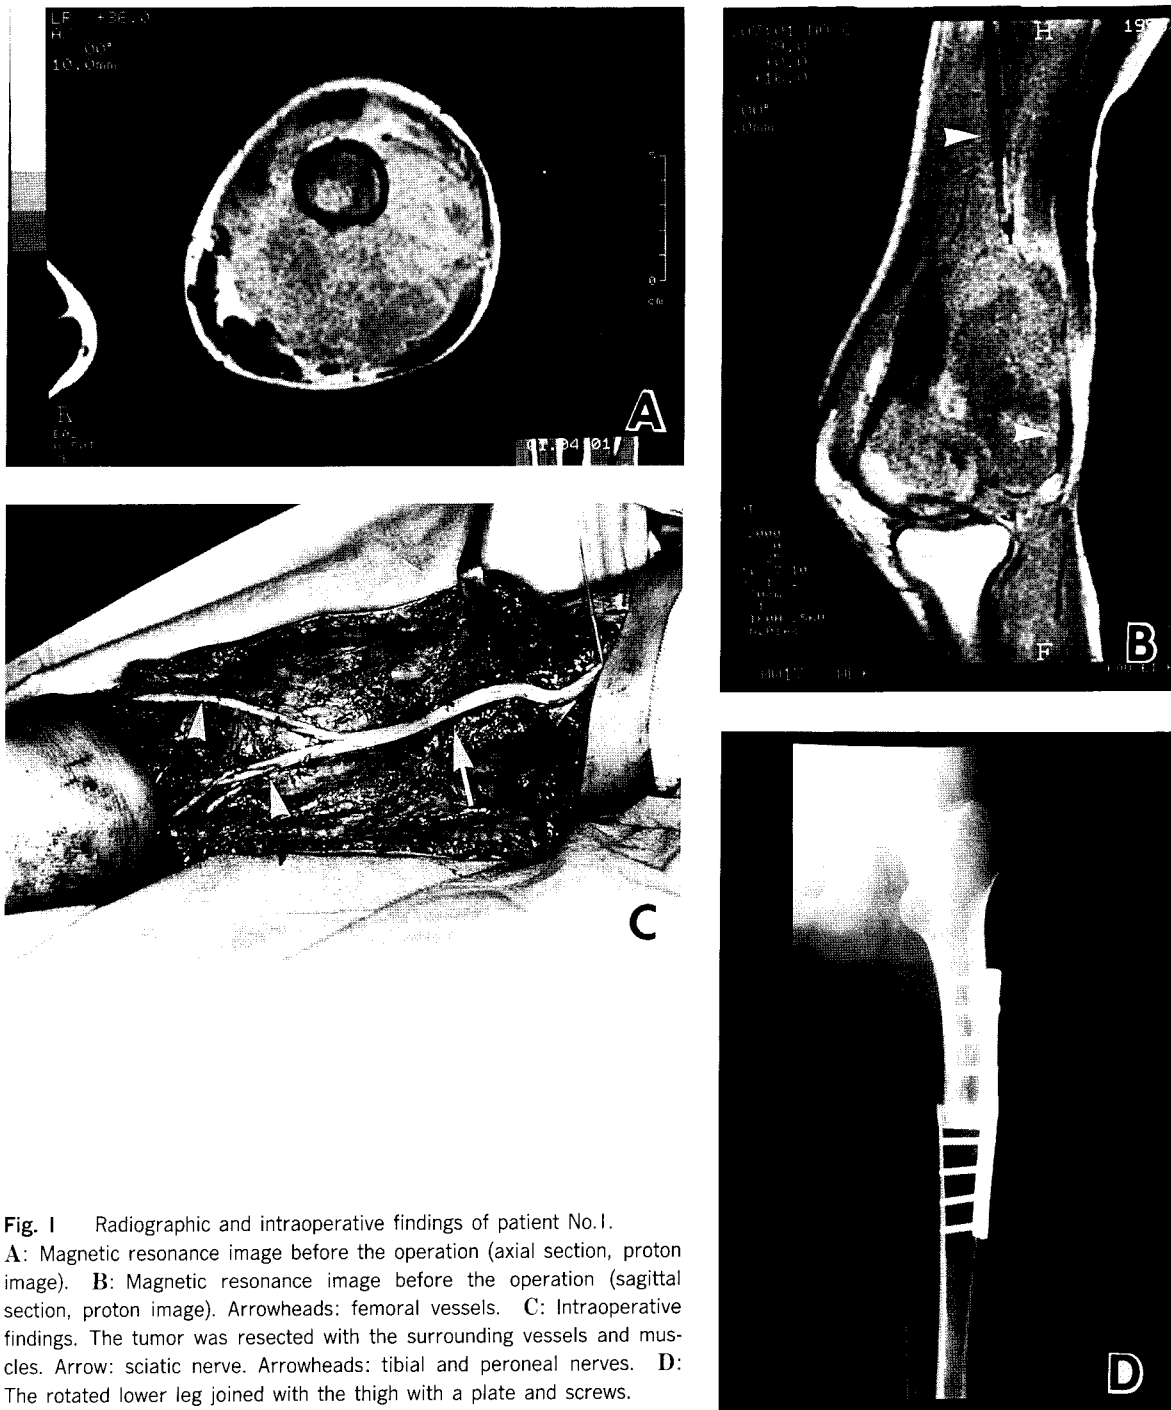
Radiographic and intraoperative findings of patient No. 1. A: Magnetic resonance image before the operation (axial section, proton image). B: Magnetic resonance image before the operation (sagittal section, proton image). Arrowheads: femoral vessels. C: Intraoperative findings. The tumor was resected with the surrounding vessels and muscles. Arrow: sciatic nerve. Arrowheads: tibial and peroneal nerves. D: The rotated lower leg joined with the thigh with a plate and screws.
